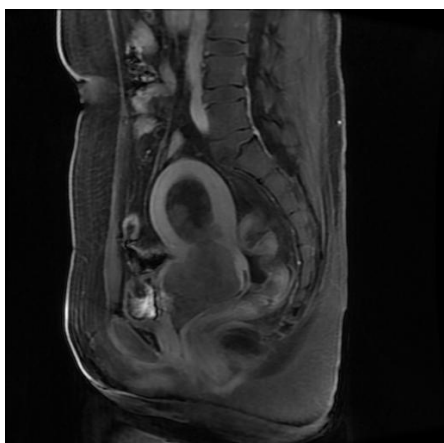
Magnetic resonance imaging showing, thick ring enhancement after I.V contrast injection. The uterine cavity is markedly widened and measures 52.0 mm × 31.9 mm and shows heterogeneous signal intensity and heterogeneous enhancement after I.V contrast injection
